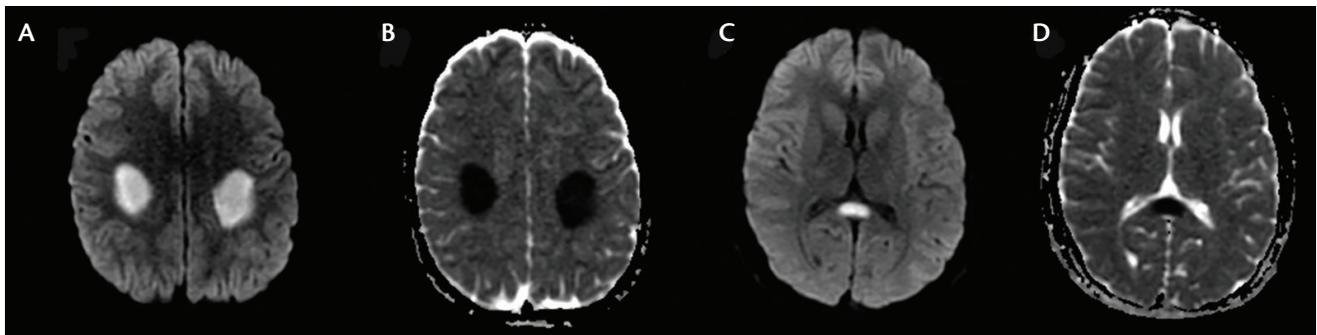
Brain MRI at 11 years of age. Diffusion-weighted image sequence (A, C) and apparent diffusion coefficient (B, D) showing restricted diffusion in the centrum semiovale (A, B) and the splenium of the corpus callosum (C, D).
